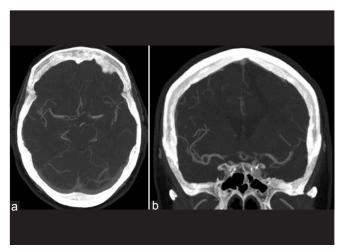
Axial (a) and coronal (b) CT angiogram images 14 months following a right-sided carotid endarterectomy disclose spontaneous regression/thrombosis of the aneurysm
